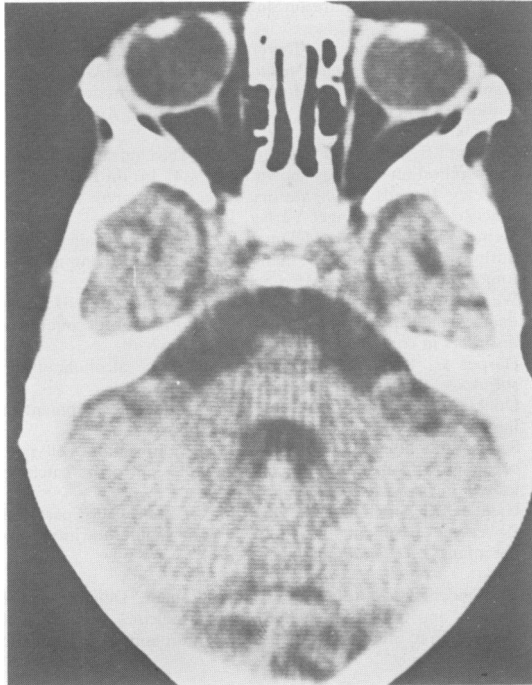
Computed tomogram of case 6, showing relative sparing of the cerebellum.*
